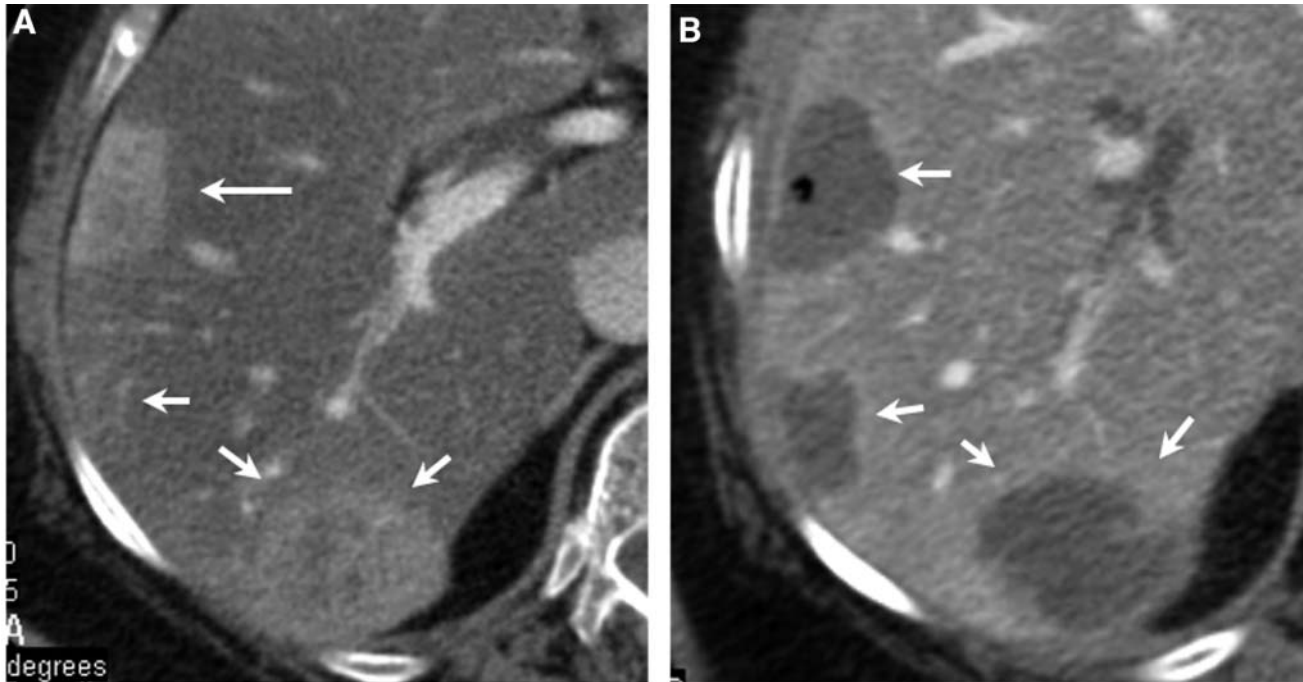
A) CT scan showed three hypervascularized hepatic nodules (arrows). B) CT scan after 1 month showed absence of intra-lesional contrast enhancement.
